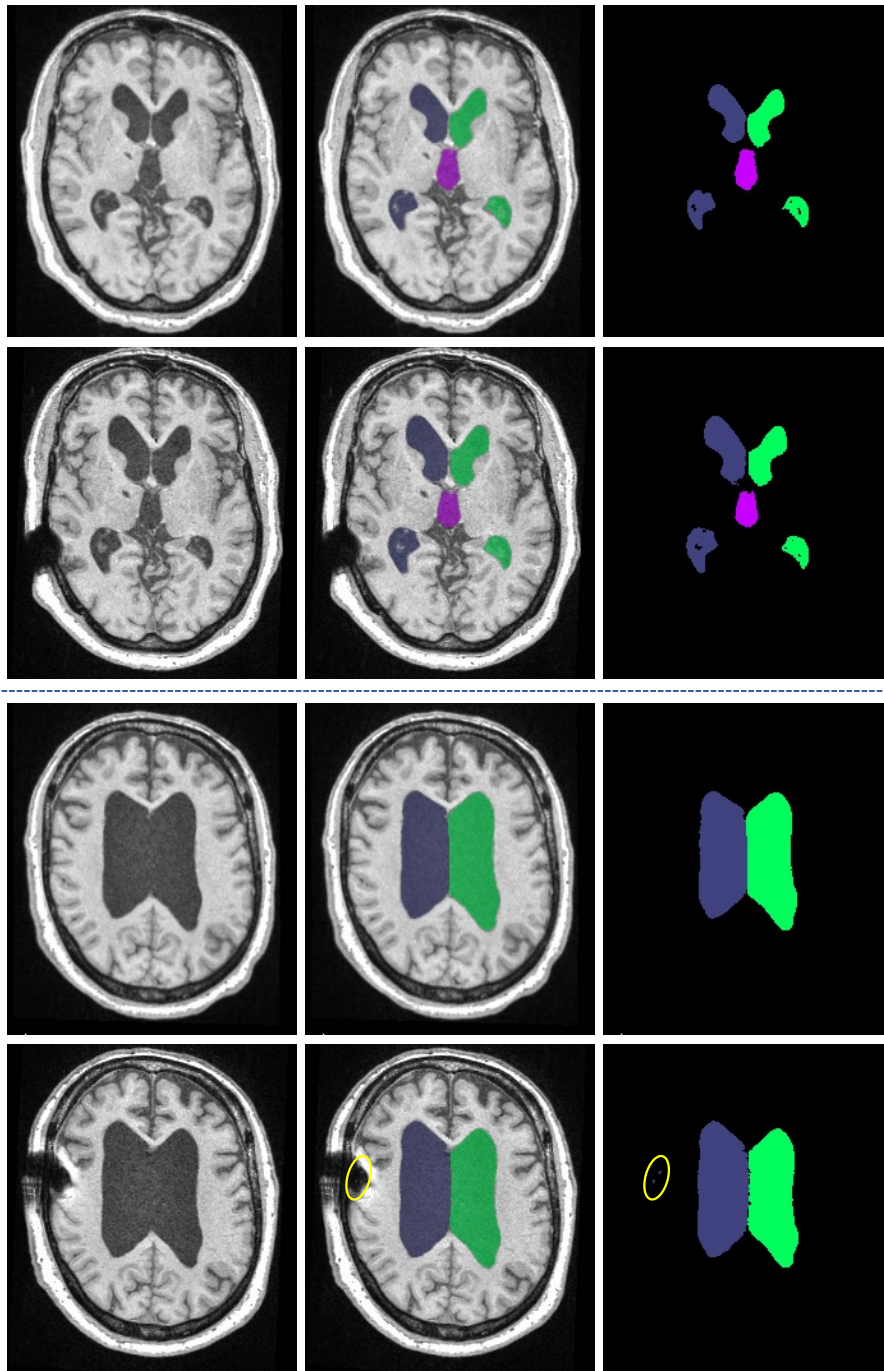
Two axial T1-w MR image slices and their corresponding VParNet parcellation results of a subject in a clinical study. In each slice, the top and bottom rows show the images before and after the shunt surgery, respectively. From left to right of each row: T1-w MR image, T1-w image overlaid by the parcellation result, and the parcellation result. The yellow contour points to small false positive regions.
